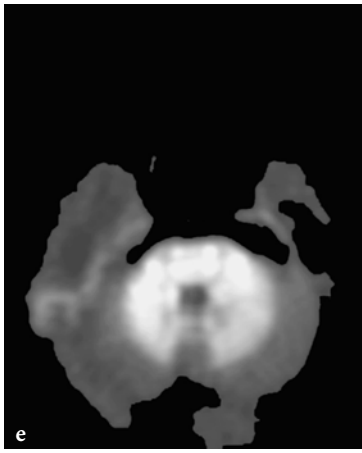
Conventional and diffusion-weighted imaging of the different edema types in maple syrup urine disease. a–d Axial T2-weighted fast spin-echo images. Both types of edema (vasogenic and myelin) present with hypersignal on these images. The myelin edema however, which involves the myelinated white matter structures appears to be somewhat more prominently hyperintense (note the increased signal within the pyramidal tracts (e.g., within the posterior limbs of the internal capsules) with respect to the rest of the centrum semiovale (c, d)). e–h Axial diffusion-weighted echo-planar images ($b = 1000s$). On these images, the myelin edema presents with marked hypersignal, whereas vasogenic edema is hypointense. The hyperintensities provide an accurate myelination map of the brain (posterior brainstem tracts, central cerebellar white matter, optic radiations, pyramidal tracts). i–l Apparent diffusion coefficient (ADC) map images. These images confirm the restriction of water diffusion within the areas of vacuolating myelinopathy (hyposignal) and the increased water diffusion in the areas of vasogenic edema (hypersignal)
